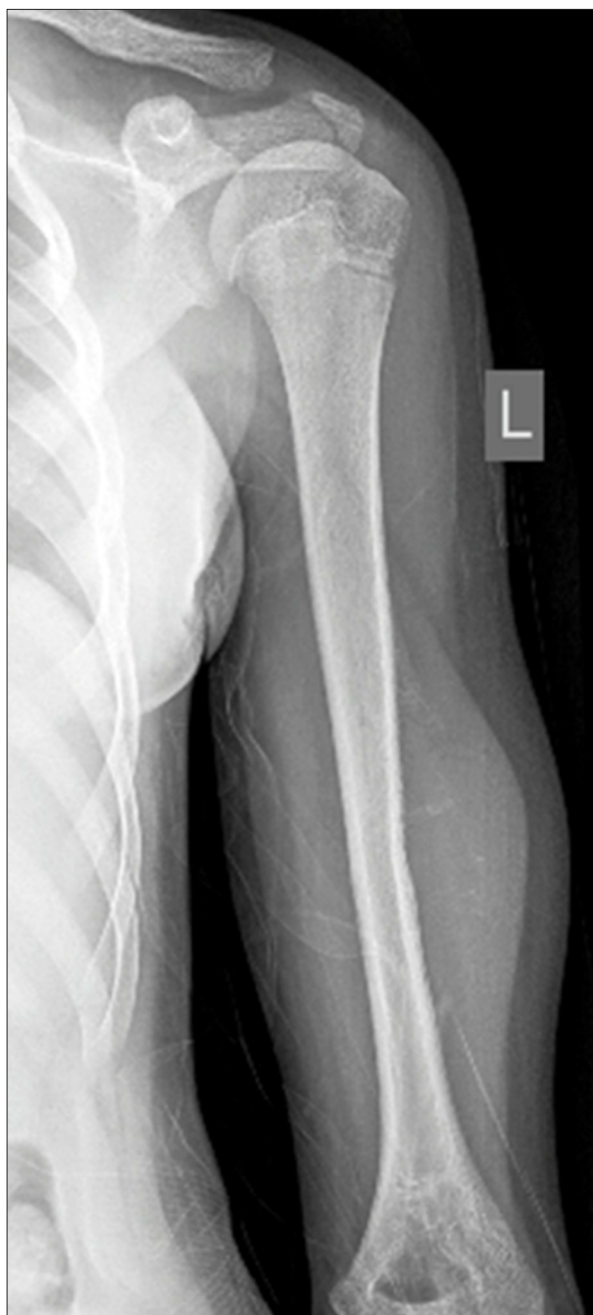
Plain radiograph of left humerus showing a soft tissue swelling with irregular cortex and periosteal reaction.
